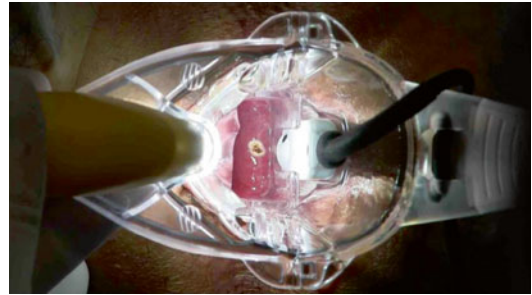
Using a diathermy to mark the site with maximal Doppler signal
